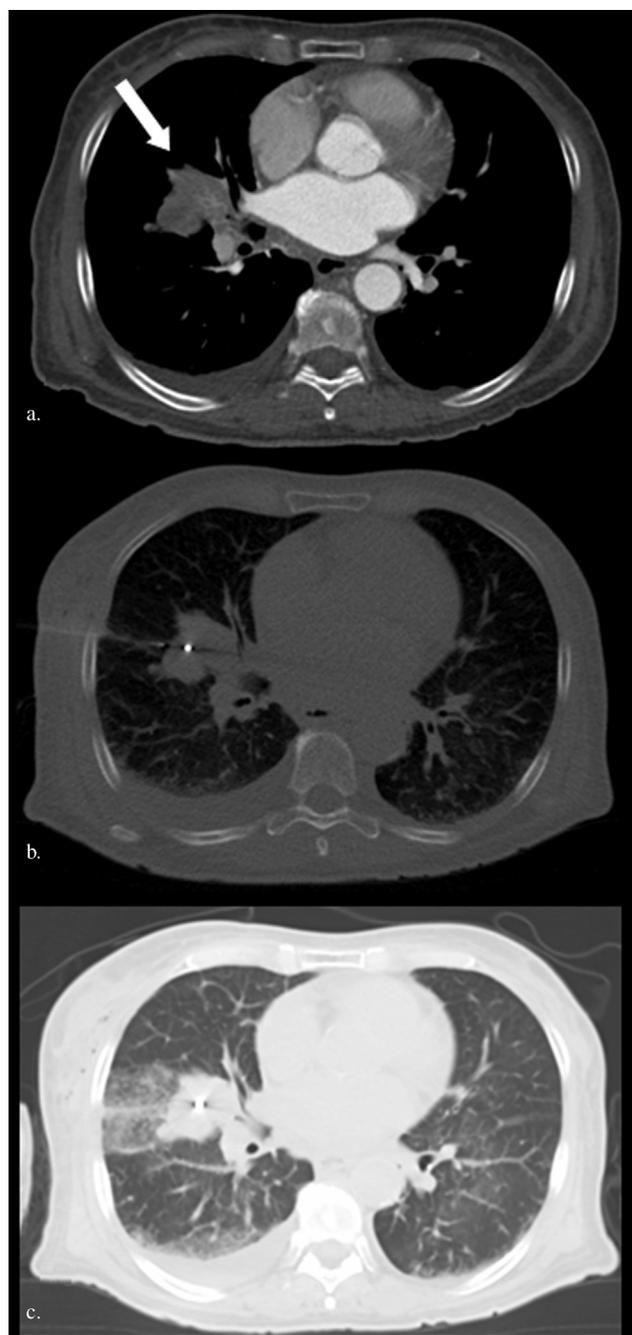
Images from a 71-year-old woman with a history of renal-cell cancer and a large metastasis (arrow) in the middle lobe abutting the right hilum (a). Under CT fluoroscopy, a fiducial seed was successfully implanted within the tumor (b). The CT scan conducted after the procedure revealed a major hemorrhage along the needle access path remaining clinically asymptomatic (c). Immediately after the procedure, the patient began to show signs of systemic toxicity associated with the local anesthetic drug, with disorientation, dysphasia, and hypertension. After instantaneous intravenous infusion of Lipofundin (B. Braun) by the anesthesiologists for the purpose of systemic binding of the local anesthetic drug, the patient was transferred to the intensive care unit for further monitoring, and was discharged the following day after complete remission of symptoms.
